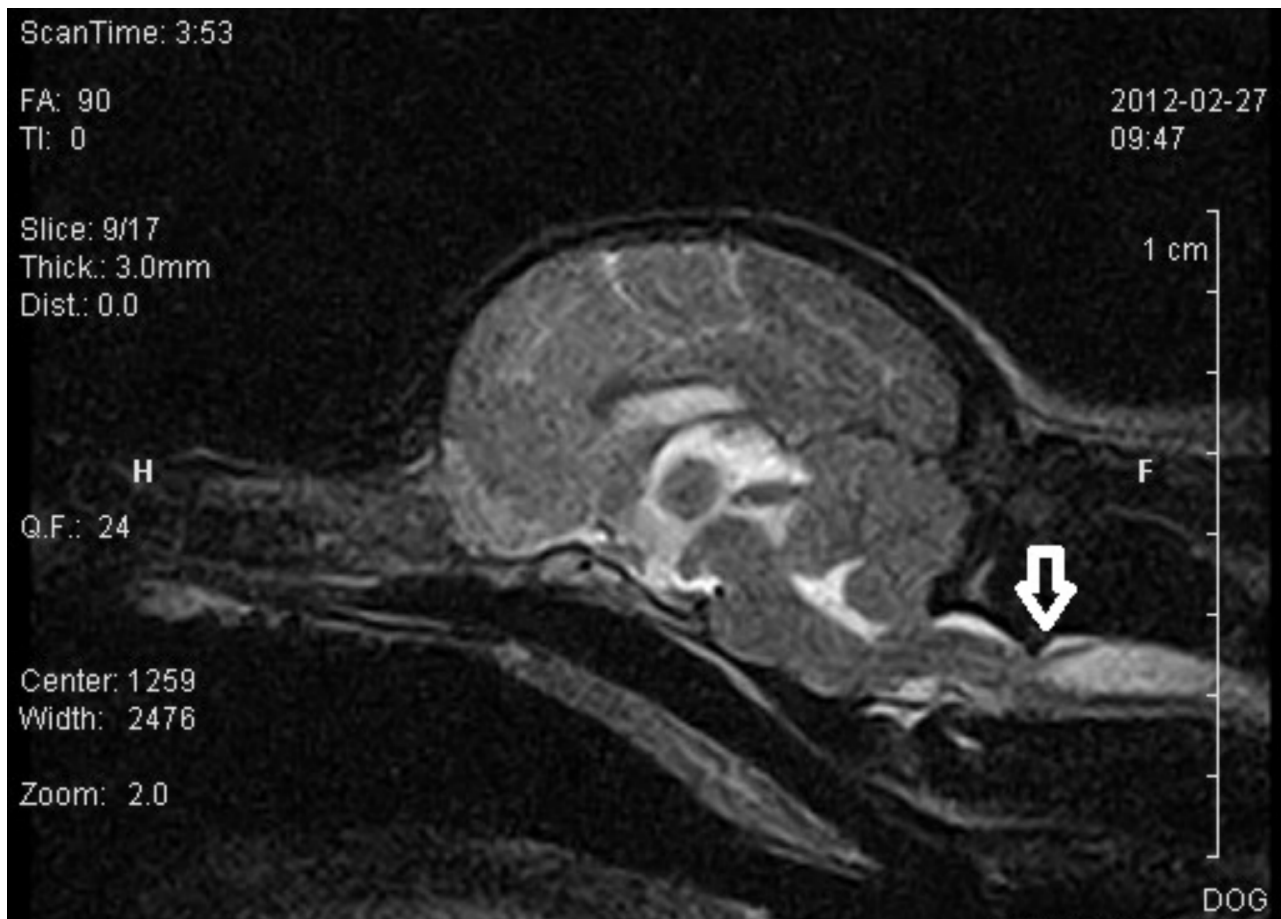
T2-weighted Fast Spin Echo in sagittal plane image of syringohydromyelia associated with Chiari-like malformation in a Cavalier King Charles Spaniel.
